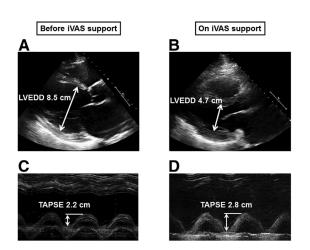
A patient who received transthoracic echocardiography before (A, B) and on (C, D) intravascular ventricular assist system support. (A, C) Parasternal long-axis views, showing a decrease in left ventricular end-diastolic diameter from 8.5 cm to 4.7 cm. (B, D) M-mode views oriented at the junction of the tricuspid valve plane and the right ventricular free wall, showing an increase in tricuspid annular plane systolic excursion from 2.2 cm to 2.8 cm.
